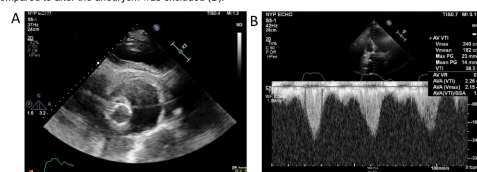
A) Preoperative transthoracic echocardiography demonstrating compression of the left ventricle by the thoracoabdominal aortic aneurysm. B) Preoperative pulsed-wave Doppler measurements using transthoracic echocardiography demonstrating a normally functioning bioprosthetic aortic valve.
